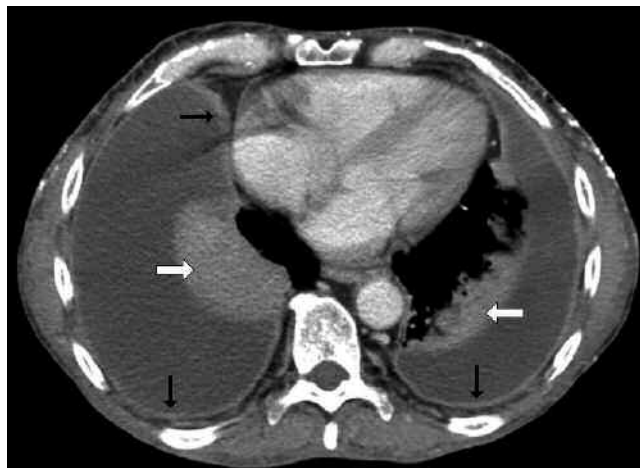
Contrast enhanced chest CT showing bilateral pleural effusions with extensive pleural enhancement (black arrows) and passive atelectasis (white block arrows).
